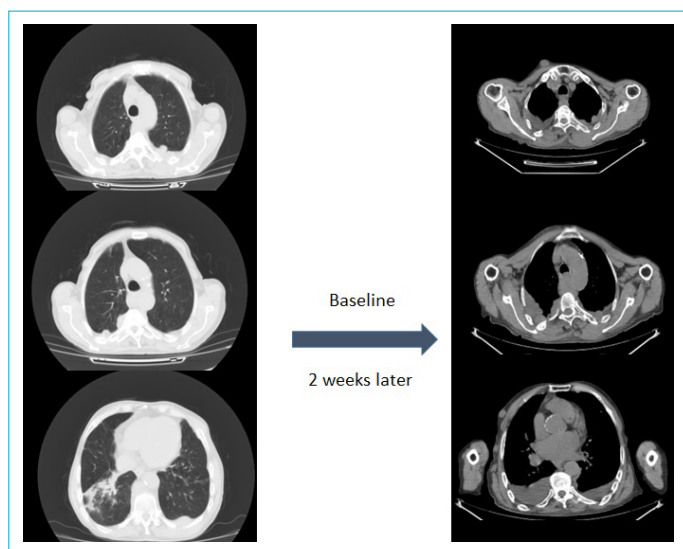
Baseline and 2 weeks later thorax CT imaging of progressive disease.
